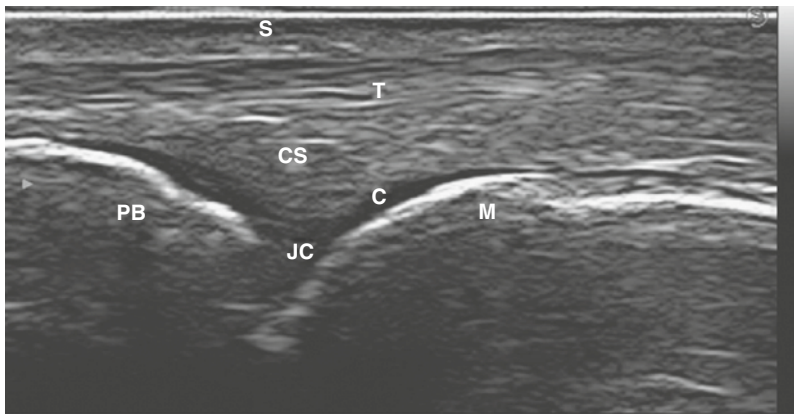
DORSAL ASPECT OF THE METACARPOPHALANGEAL JOINT. Ultrasound shows the dorsal aspect of the metacarpophalangeal joint in the sagittal plane. C, hyaline cartilage; CS, central slip; JC, joint cavity; M, metacarpal head; PB, phalangeal base; S, skin; T, extensor tendon.
